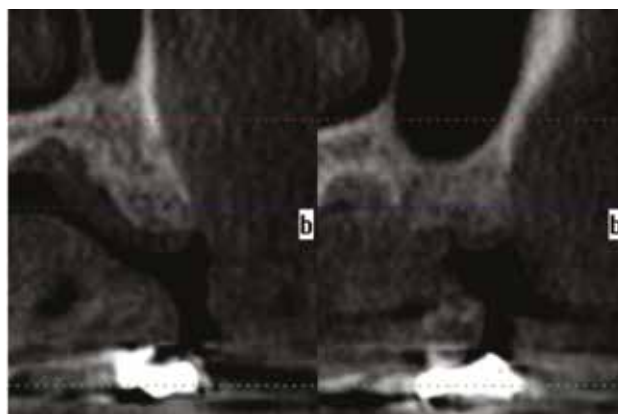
CBCT cross section of the grafted sockets 4 months post treatment following 5 minutes of LMHFV usage demonstrating increased density of the grafted sites.
